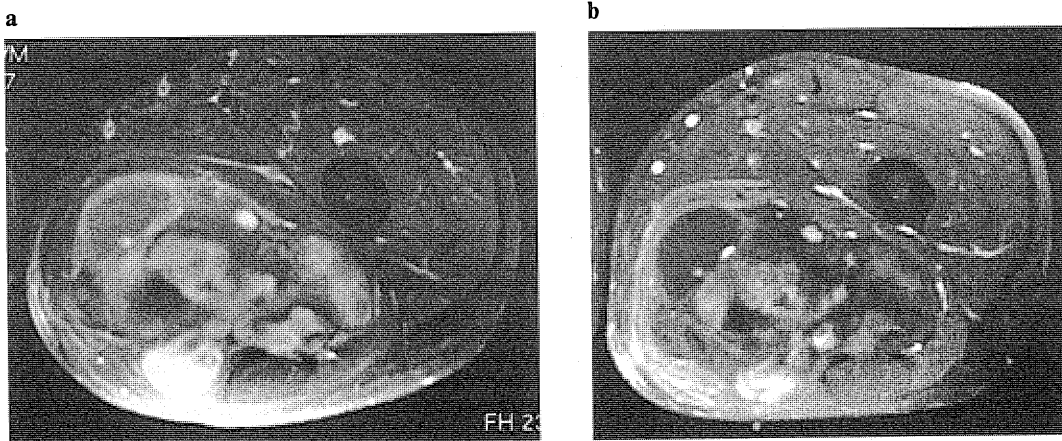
T2-weighted images show a large tumor seated in the deep region of the left thigh. a, T2WI Transverse image ; b, T2WI Coronal image.
